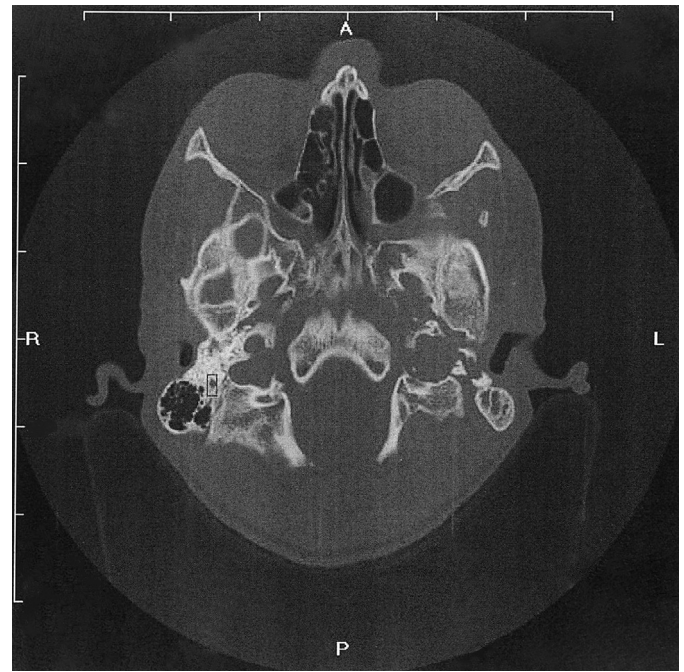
Axial computed tomography scan showing large bony defect of the left jugular foramen.
